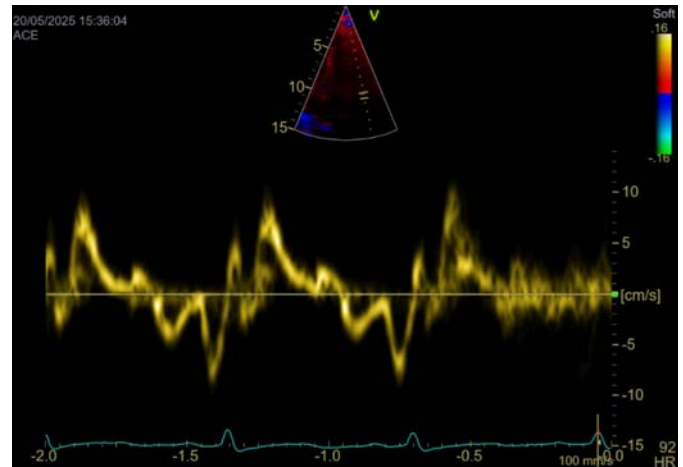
Tissue Doppler imaging of the mitral annulus demonstrating reduced lateral e' velocity (5 cm/s).
